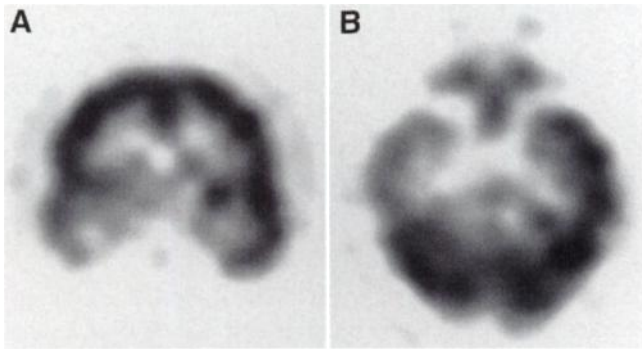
Selected coronal (A) and transverse (B) views (FDG) of the brain of 36-y-old woman with right temporal lobe epilepsy. Images were acquired in 30 min in two-dimensional mode with dual-head scintillation camera operating in coincidence mode.
